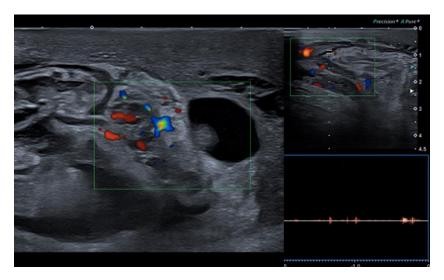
Ultrasound reassessment 24 hours post-embolisation. Images show patency of vessel proximal to the embolisation point.
